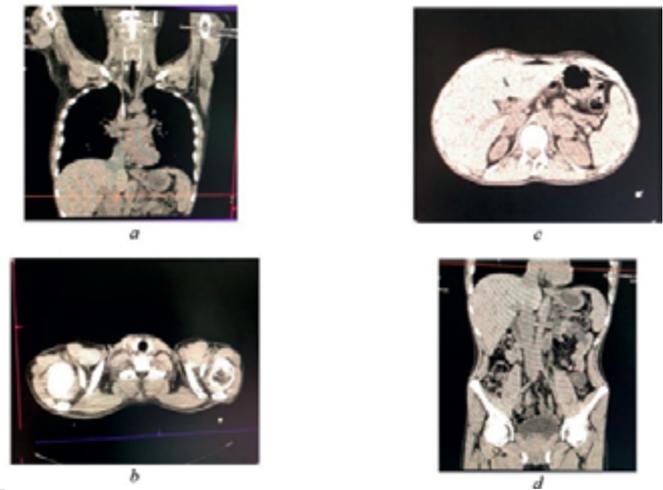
Multispiral CT after the treatment of patient M: (a) Multispiral CT of the neck after the treatment; (b) Multispiral CT of the chest area after the treatment; (c) Multispiral CT of the abdominal cavity before treatment; (d) Multispiral CT of the abdominal cavity before treatment.
